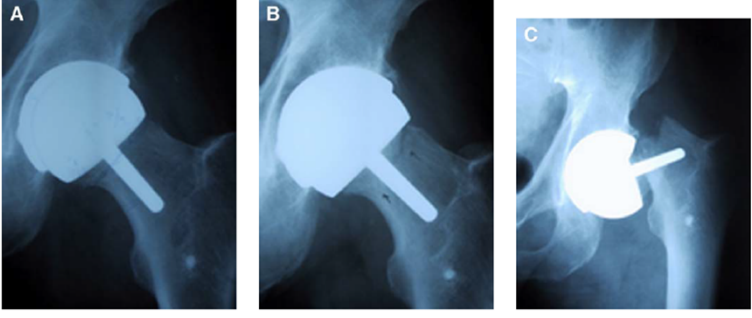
(A) Postoperative radiograph of a femoral head prepared with a notch in the superior neck that may have contributed to the propagation of a fracture as seen evolving 6 weeks post surgery (B) and 10 weeks post surgery (C).
